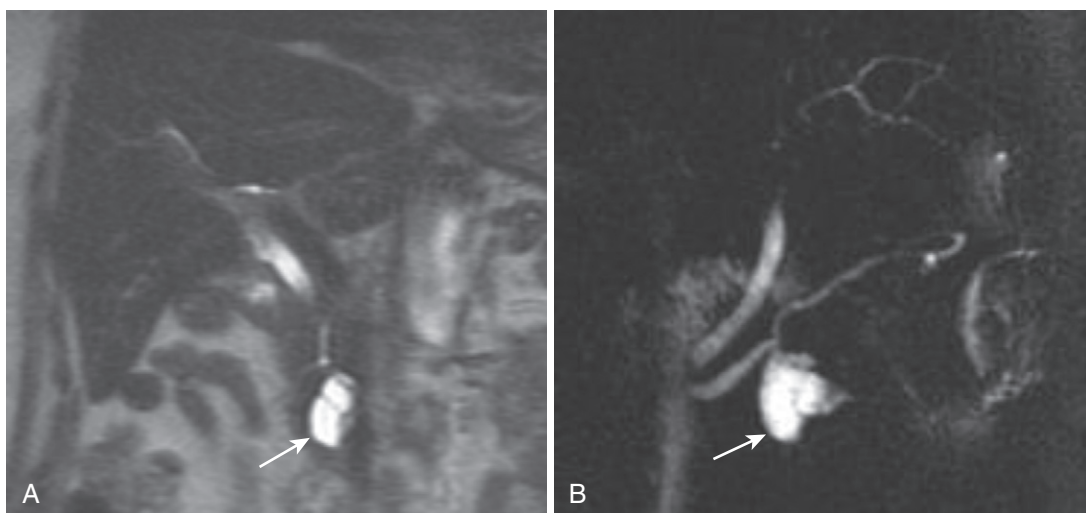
IPMN side branch type. The coronal T2-weighted image (A) shows a simple-appearing cystic lesion in the pancreatic head (*arrow*). The corresponding MRCP image (B) depicts the connection with the main pancreatic duct and characteristic downstream dilatation (*arrow*).
